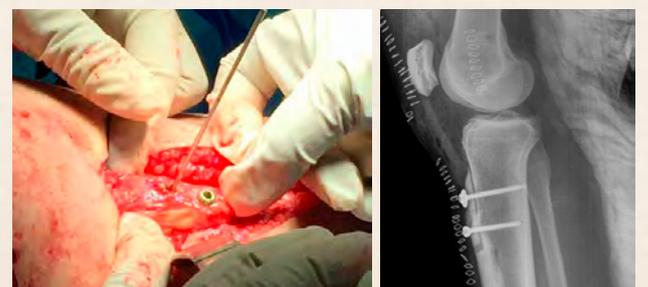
The tibial tubercle was osteotomized obliquely and fixed in the new position through 2 cortical screws (a) (b. post-operative x-ray).
